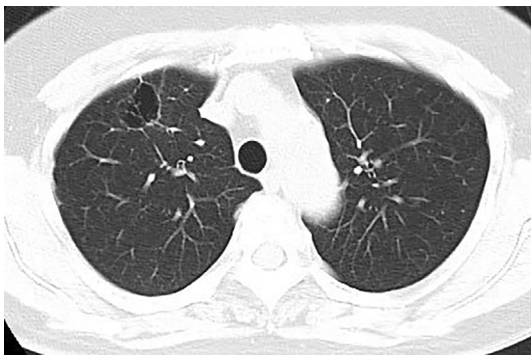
Chest computed tomography showing the disappearance of the pulmonary lung tumor two months after starting treatment with afatinib.
